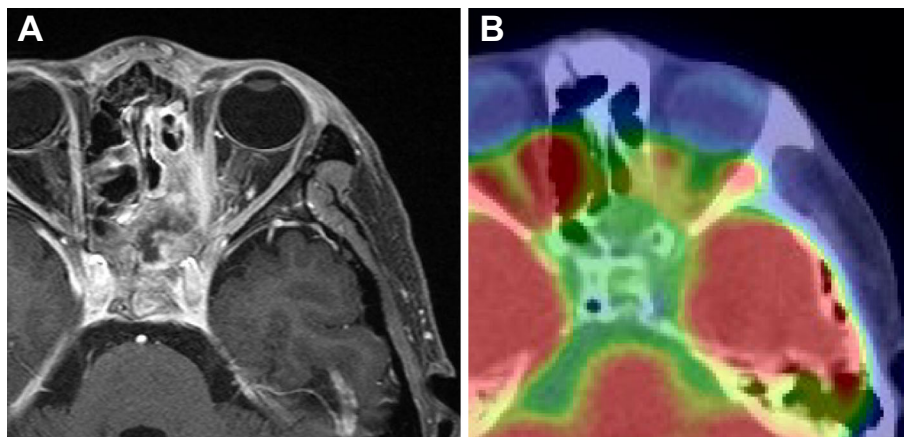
Magnetic resonance imaging (MRI) (A) and positron emission tomography (PET)-computed tomography (CT) (B) after treatment. MRI and PET-CT did not reveal any abnormalities with signs of relapse.
